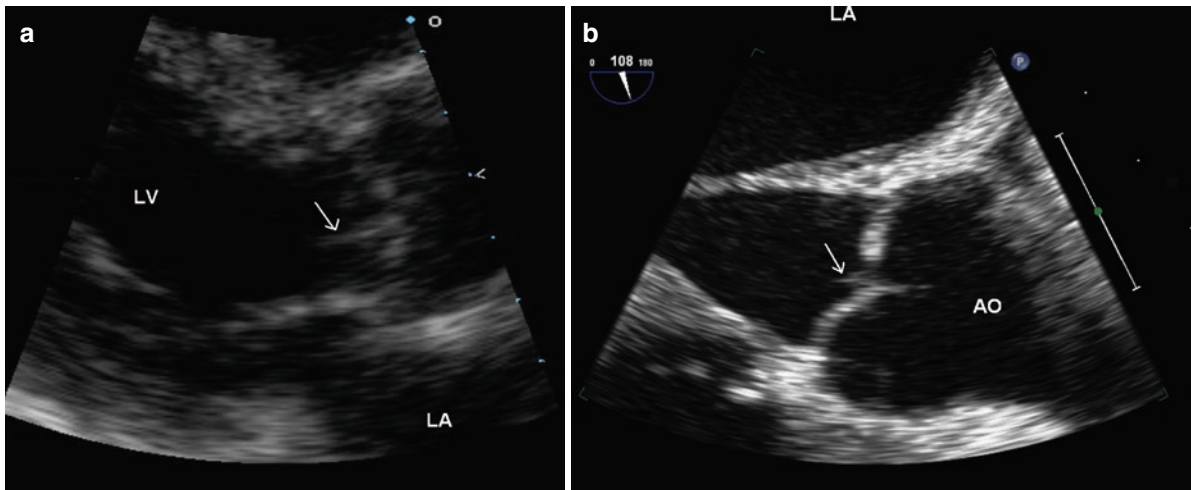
The parasternal long-axis view (a) of a 43-year-old woman shows that there is long linear density (arrows) attaching to the tip of the aortic valve and prolapsing into the left ventricular outflow tract in diastole. Color flow imaging shows no aortic regurgitation (b). This linear mobile density likely represents a ruptured aortic fenestration. *LA* left atrium
